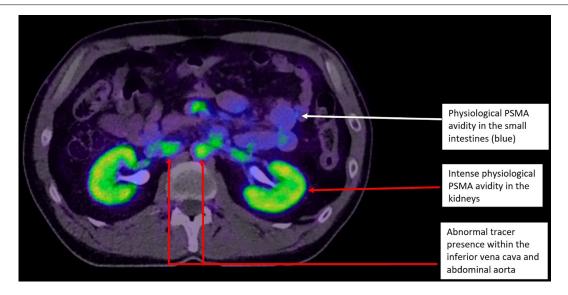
An axial section of AM's PSMA PET scan demonstrating tracer distribution in the renal parenchyma, inferior vena cava and abdominal aorta. There is also background less intense physiological uptake by the small intestines (blue).
